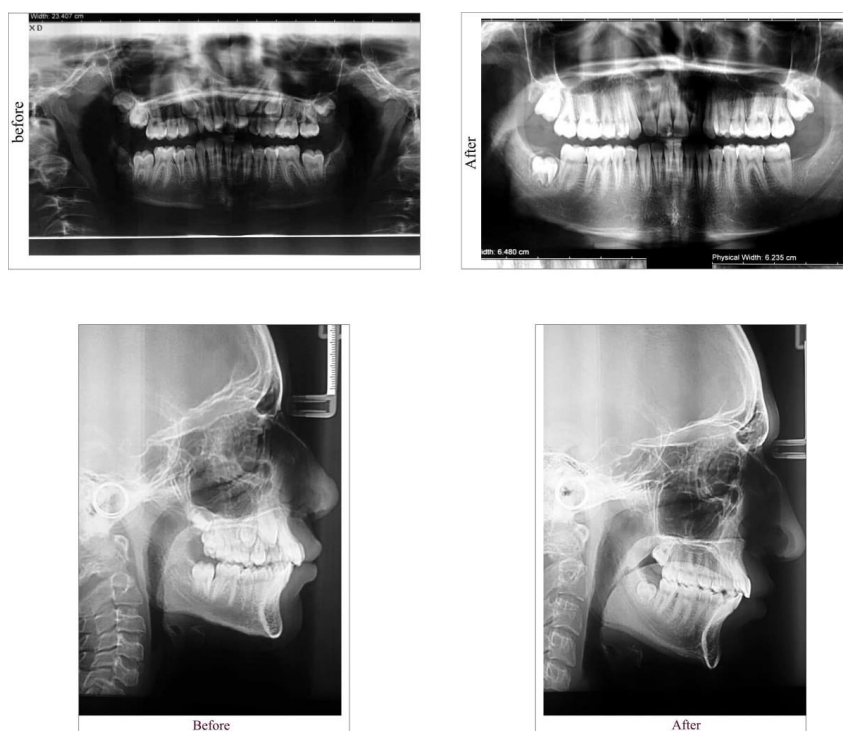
(Case II): Before and after treatment radiography in a 12 years old boy
